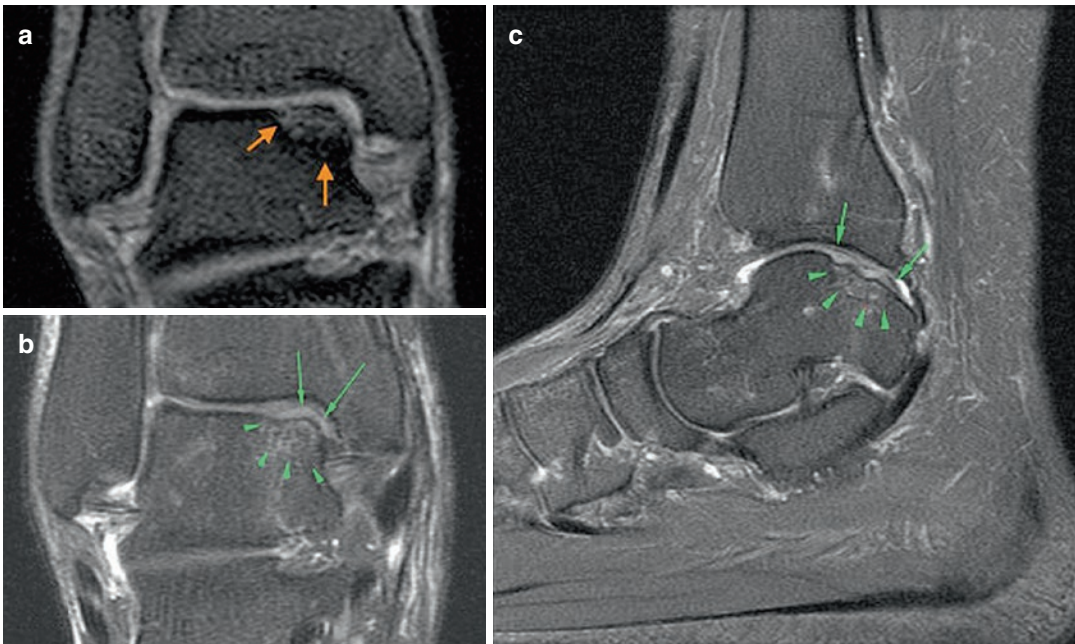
After 12 months MRI 3,0T scans of reconstructed OCL (a) orange arrows – bone margin of the reconstructed OCL talus, (b, c) green arrows – cartilage regenerate, green arrowheads – bone part of the reconstructed OCL talus
